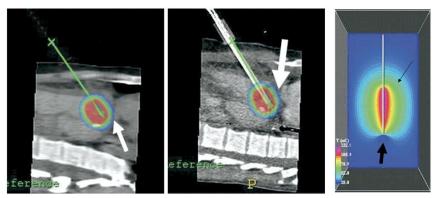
Colorized isotherms superimposed on CT images of ablation needles [8]
